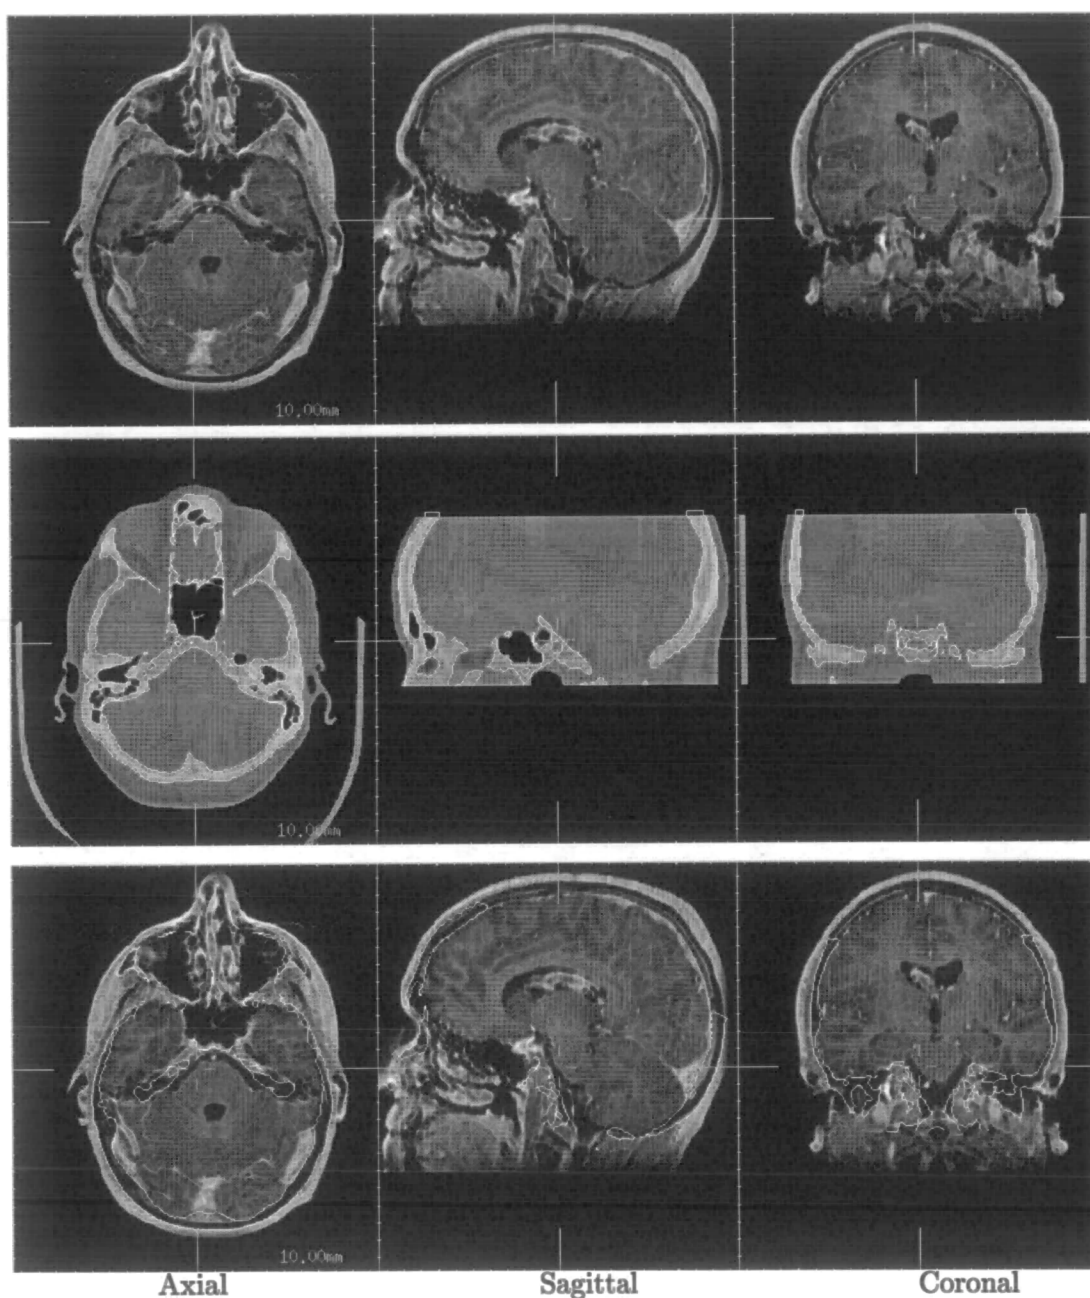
Inspection of a manual point based MR-CT registration estimate by interactive selection of a CT contour level (middle) to delineate bone surface. This is then overlaid using the transformation estimate onto the MR (bottom.)
